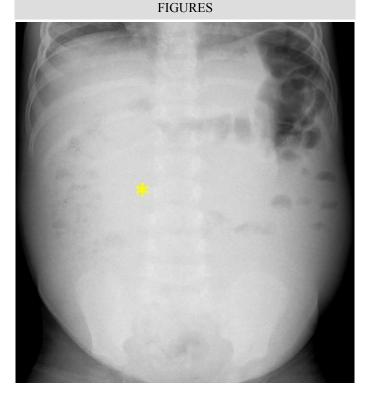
Two year old boy with mesenchymal hamartoma of the liver. Upright plain abdominal radiograph demonstrates a large, soft tissue density abdominal mass, extending through the right hypochondrium, epigastrium and umbilical region, crossing the midline and displacing bowel loops to the periphery of the abdominal cavity.
